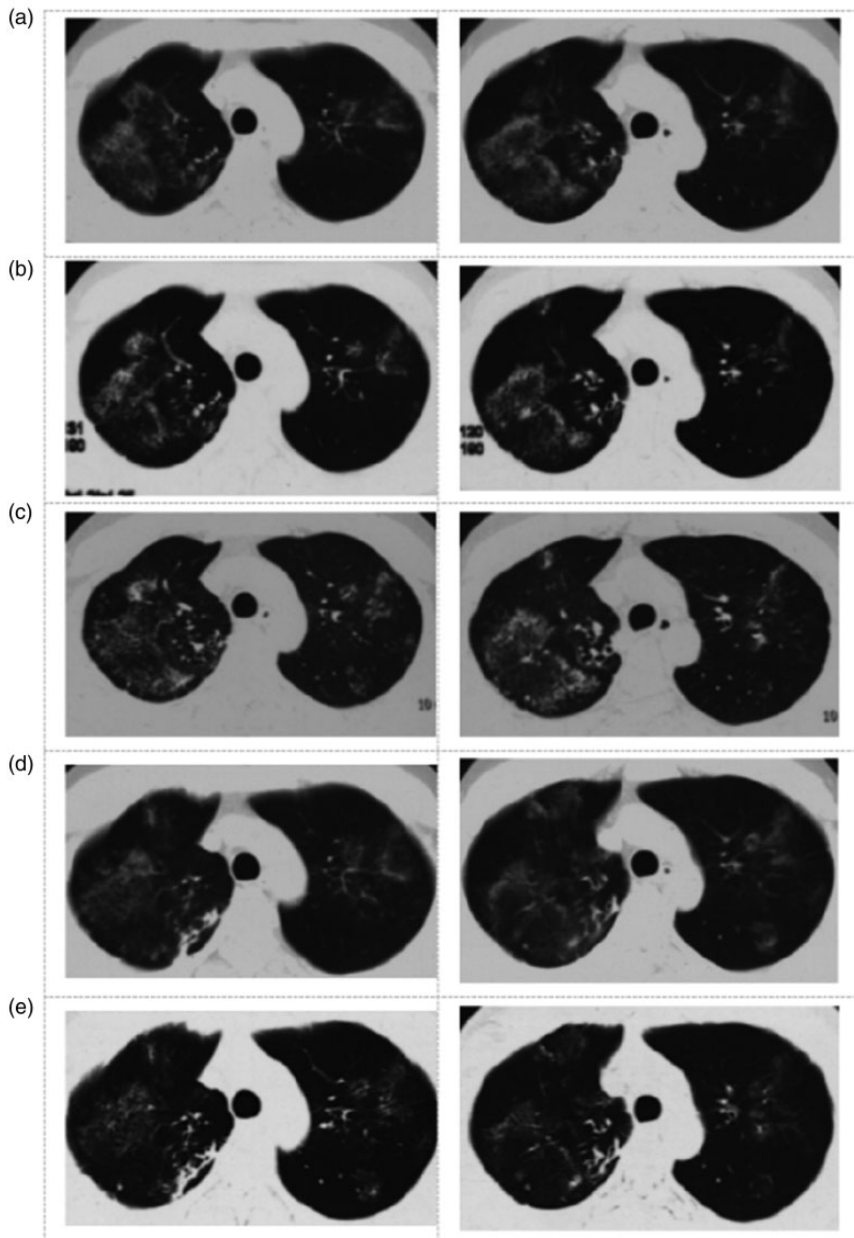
Chest computed tomography (CT) images of a male patient: (a–c) images taken before his first hospitalization showing three CT scans taken at incremental time-points over 9 months after the accidental discovery of lung lesions (a: 9 September 2014; b: 17 September 2014; c: 15 May 2015). The CT images show persistent multiple ground glass opacity in both lungs with little change between the three time-points, especially in the right lung and (d & e) images from 4 and 6 months after hospital discharge showing focused shrinkage and less dense lesions (d: September 2015; e: November 2015).
